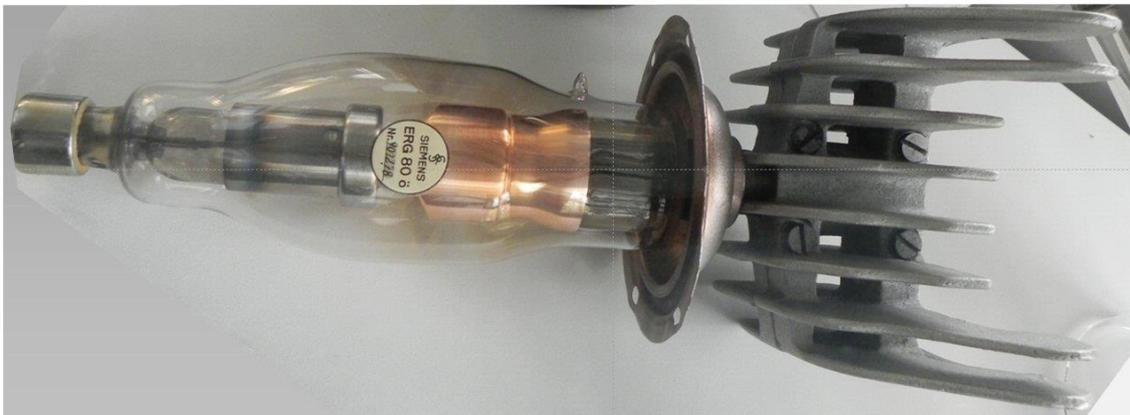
Siemens stationary anode tube ERG 80 ö with cooling fins from 1942. (Photo taken in the Siemens X-ray tube museum Rudolstadt, Germany.)
